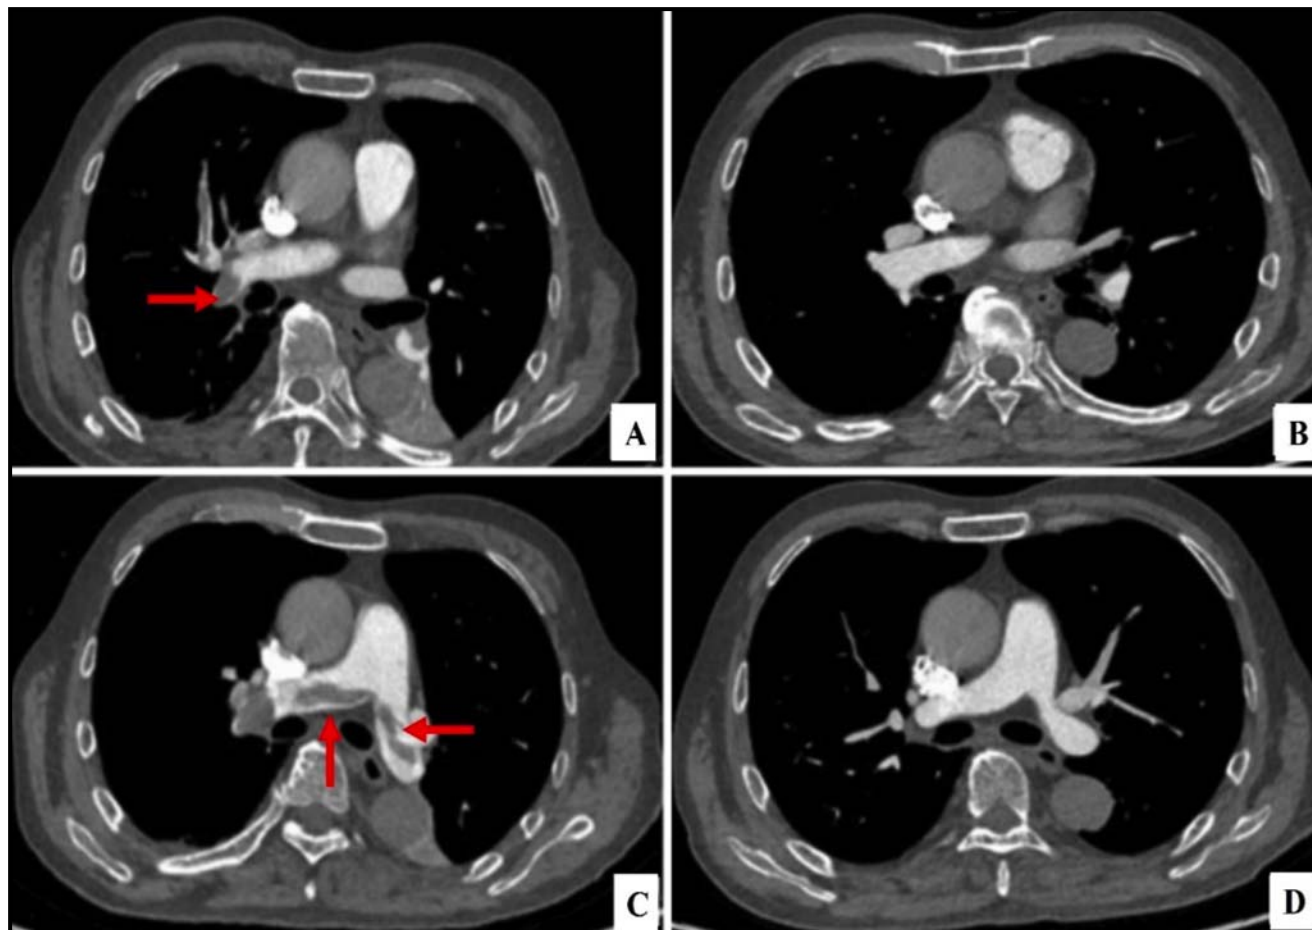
Pulmonary artery CT angiography (CTA) before and after anticoagulation therapy. 5A, 5C: CTA acquired on day 4 of rehabilitation hospitalization (day 21 post-ICH onset), demonstrating multiple filling defects in both pulmonary arteries consistent with bilateral pulmonary thromboembolism, including a straddling embolus at the main bifurcation. Hemodynamic instability (BP 82/45 mmHg, SpO₂ 91%) was present at the time of this study. 5B, 5D: Follow-up CTA acquired 17 days after initiation of low-dose heparin sodium anticoagulation, showing near-complete resolution of bilateral pulmonary emboli with no residual filling defects identified. No new intracranial hemorrhage was detected during the interval between studies.
